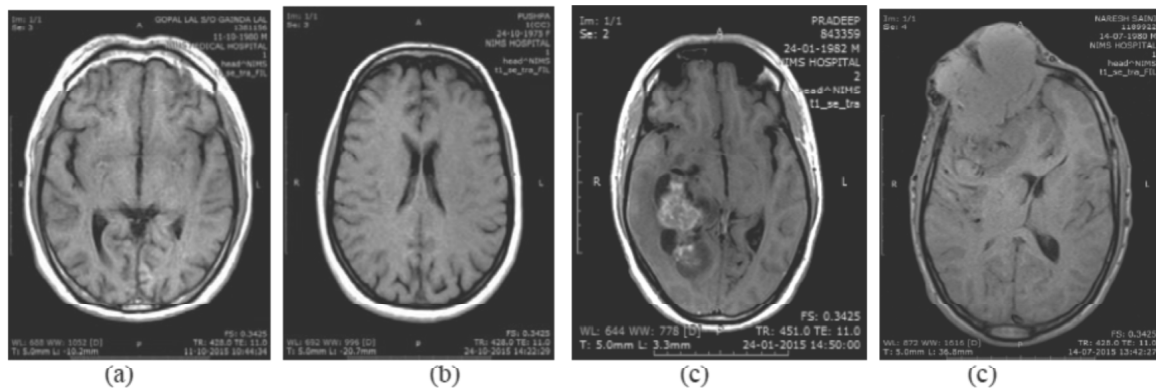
Brain MR images from training set (a) and (b) are the Normal MR images and (c) & (d) are the Abnormal MR images.
